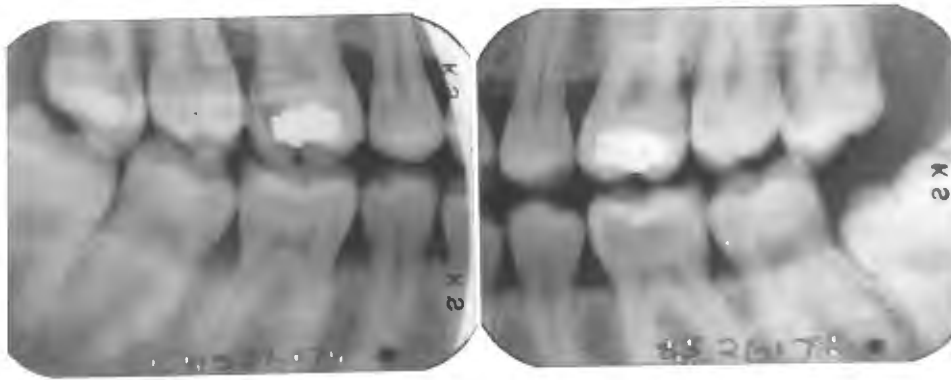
Bite-wing radiographs of affected mother of Case 5 taken at initial examination. Although she had VDRR, the dental manifestations were minimal. The pulp chambers of the teeth appeared normal and no abscesses had developed.
